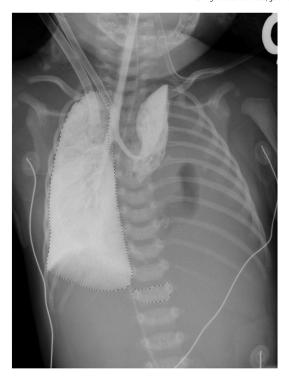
Chest radiograph of an infant with CDH on ECMO with perflubron instilled; area of left lung and L1 vertebral body selected for analysis.
